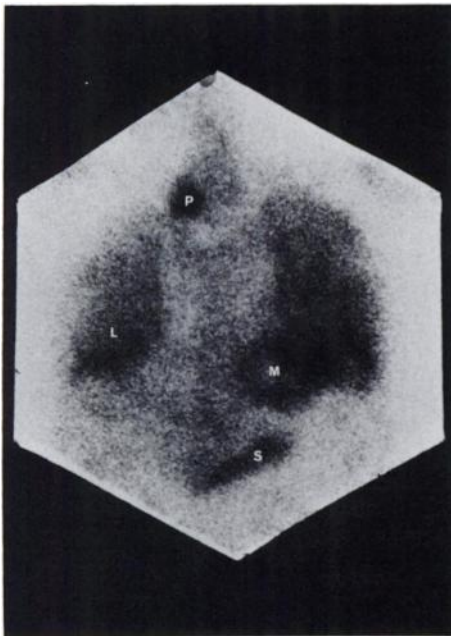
Tc-99m MDP scintigraphy. Note marked accumulation of activity in lungs (L), myocardium (M), abdominal scar (S) and the parathyroid adenoma (P).
